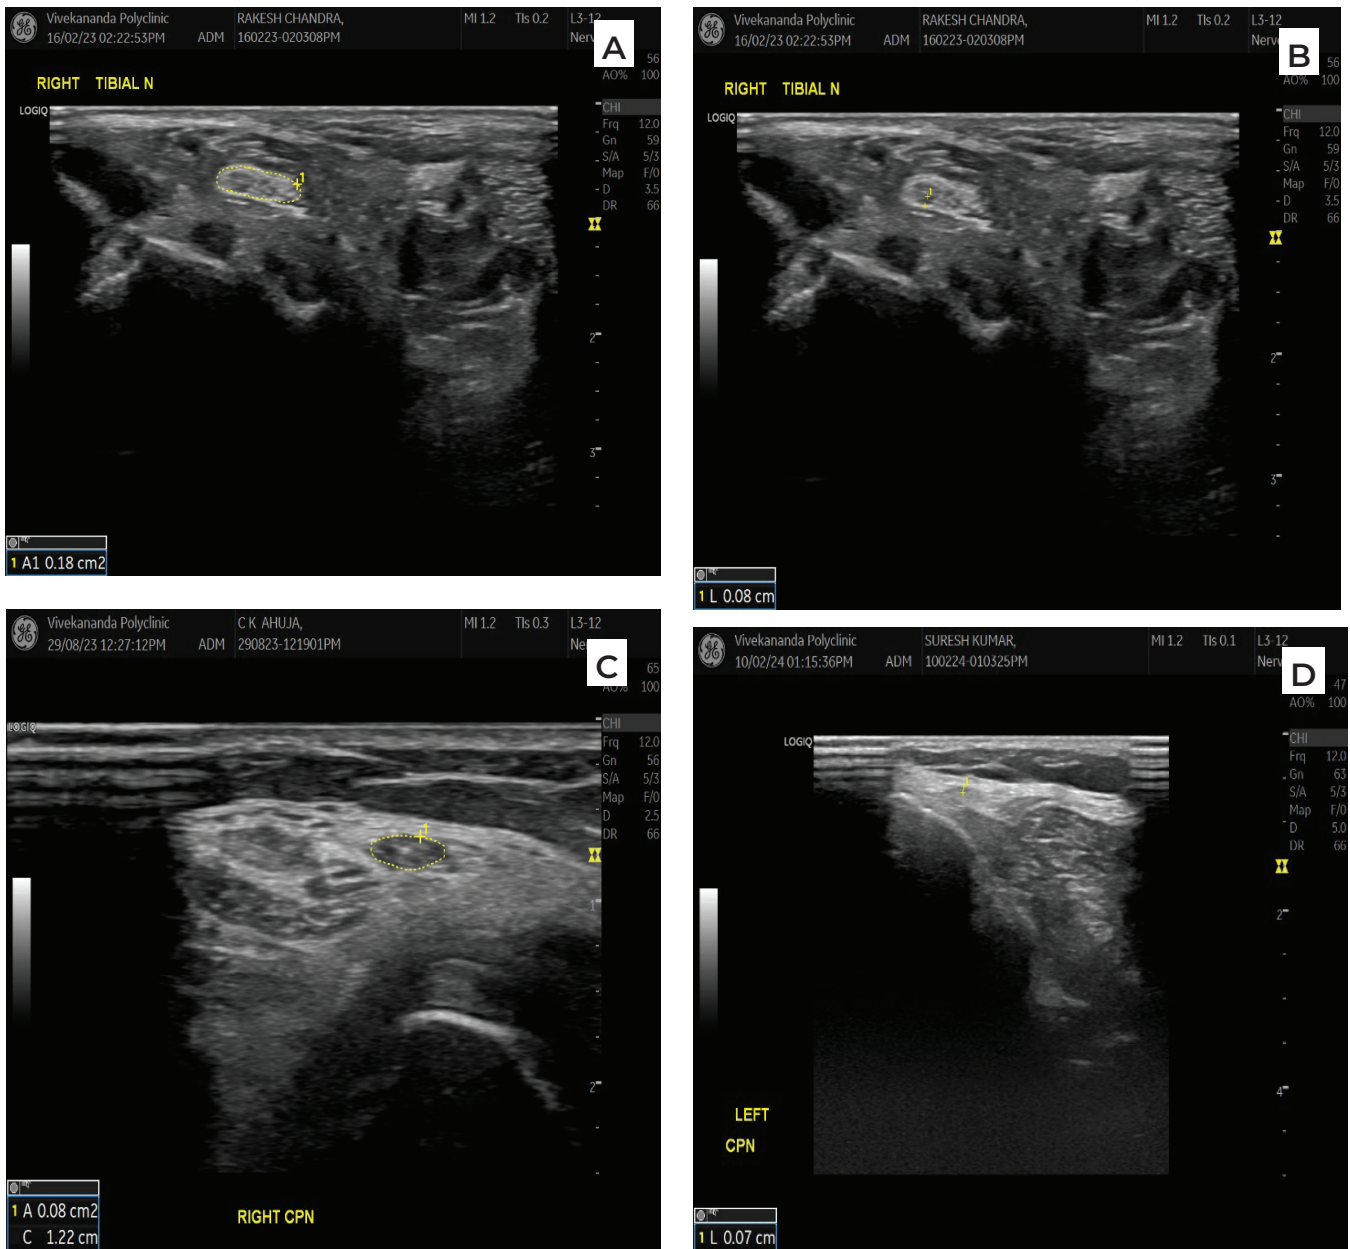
A 60-years-old female patient diagnosed with Type-2 Diabetes Mellitus 15-years back, presented with pain and numbness in both lower limbs. Her HbA1c was 8.5% and RBS was 255 mg/dL. A. A transverse sonogram view of the tibial nerve at 3 cm proximal to Medial Malleolus (MM) showing thickened tibial nerve with cross section area (CSA) measuring 18 mm². B. Mean Thickness of Nerve Fascicle (MTNF) of tibial nerve was increased measuring 8 mm. C. A transverse sonogram view of Common Peroneal Nerve (CPN) at fibular neck level showing thickened nerve with CSA of 8 mm². D. Mean Thickness of Nerve Fascicle (MTNF) of Common Peroneal Nerve (CPN) was normal measuring 4 mm.
